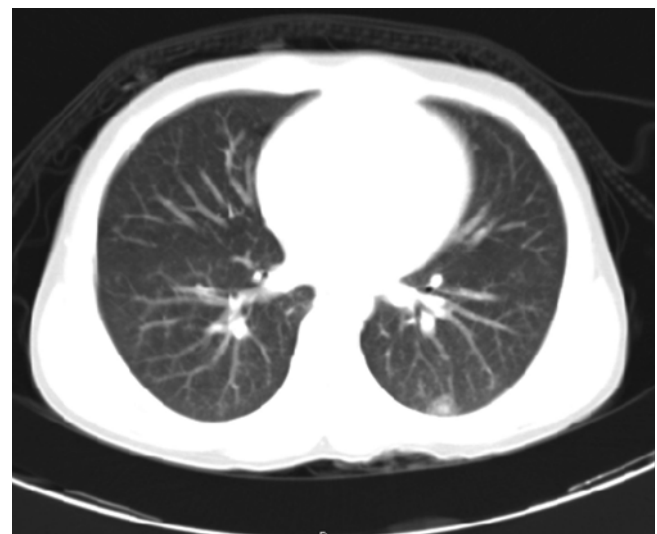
Chest CT image of an HIV infected child with nephroblastoma. Thoracoscopic biopsy confirmed the pulmonary lesion to be schistosomiasis
